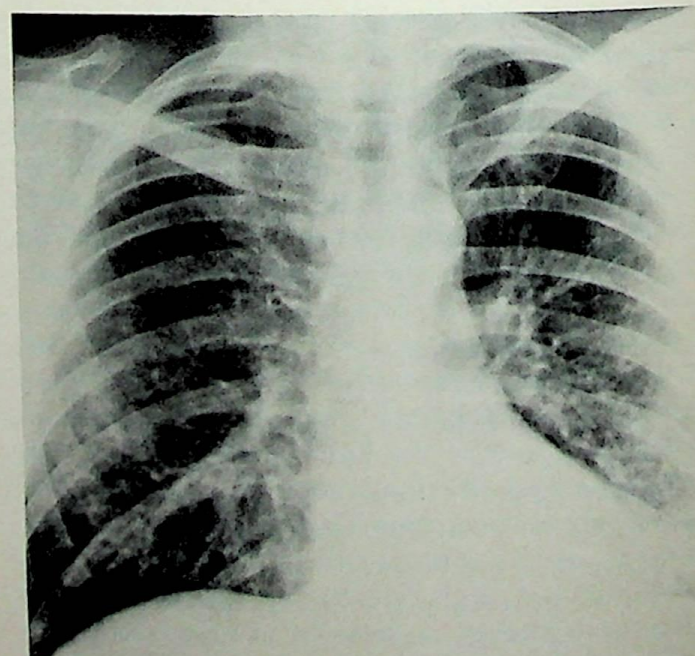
(same case as in Fig. 2 middle). Roentgenographic demonstration of diffuse interstitial pattern in patient with Churg-Strauss syndrome.
